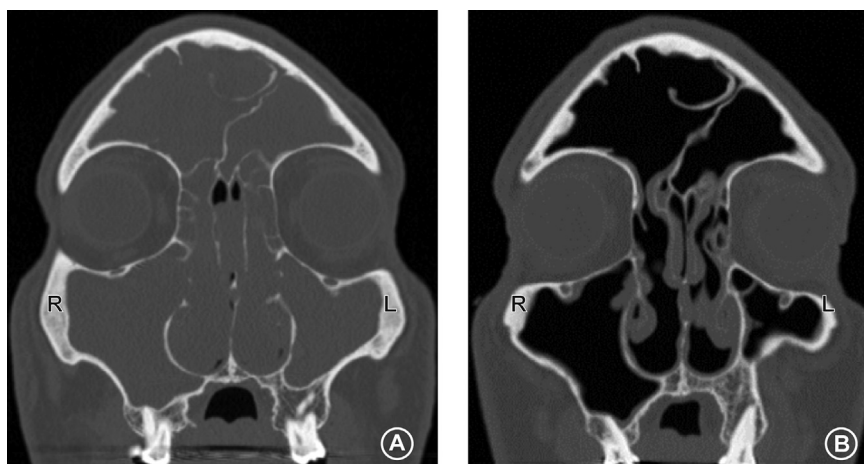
CT scan of one patient before and after therapy of dupilumab. A: before therapy; B: after therapy.
